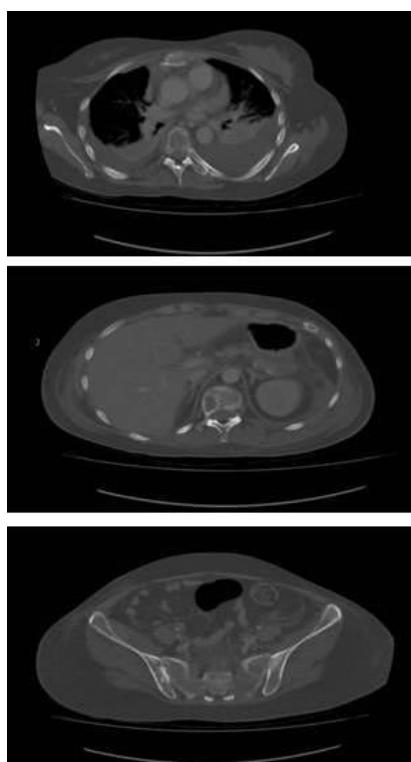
CT Scan showing multiple Lytic lesions at various levels of vertebral column and other bones.
